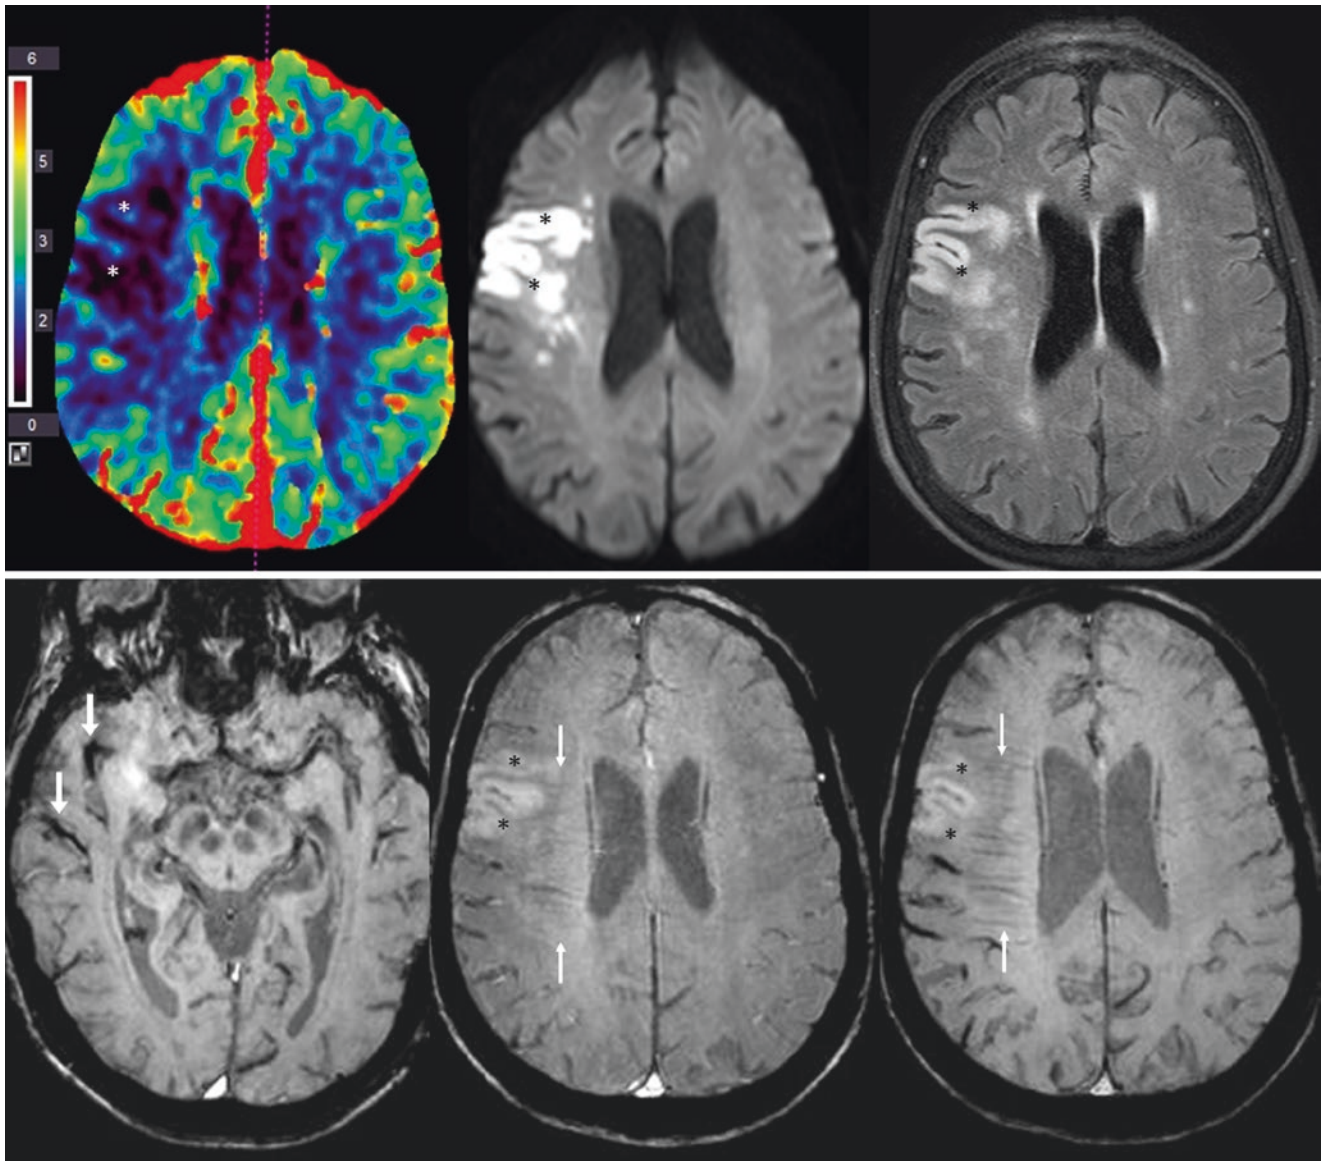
Comparison case of acute ischemic stroke. *Top row:* A 66-year-old with left-sided weakness had an infarct (*asterisks*) on a CT perfusion cerebral blood volume (CBV) map (*left*), and on 3 T MRI DWI (*middle*) and FLAIR (*right*). *Bottom row:* On SWI with a TE of 40 ms (*left*), there was darker signal within the middle cerebral artery
